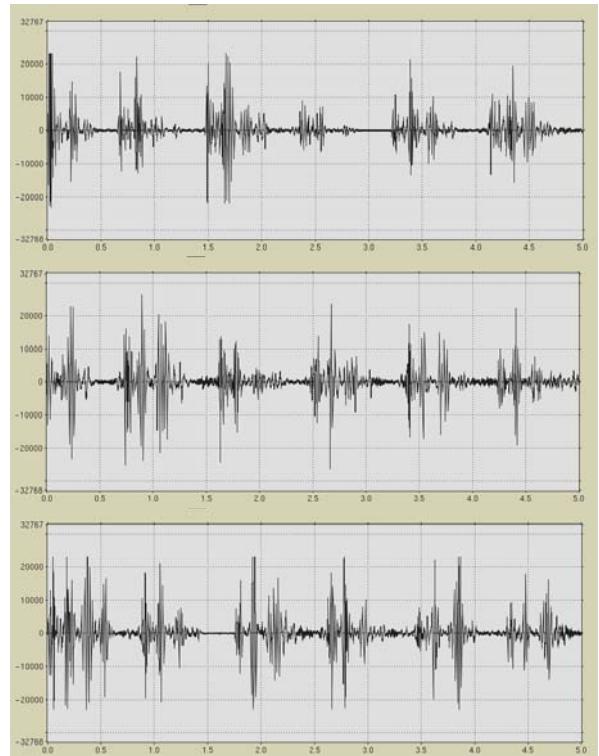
Same as Fig. 4, measured with the prototype stethoscope in the active ultrasound-Doppler mode.
